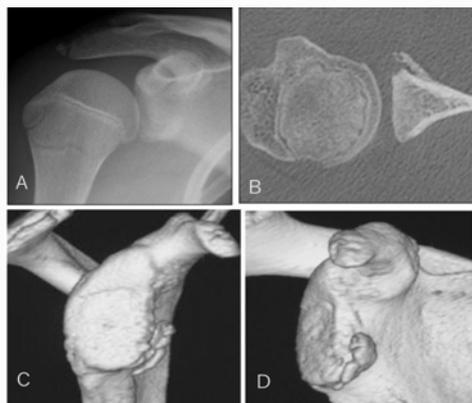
Preoperative images. (A) Plain radiograph, anteroposterior view. (B) 3D CT, sagittal view. An osseous bony lesion was observed in the anteroinferior part of the glenoid. (C) 3D CT sagittal view. (D) 3D CT axial view.
